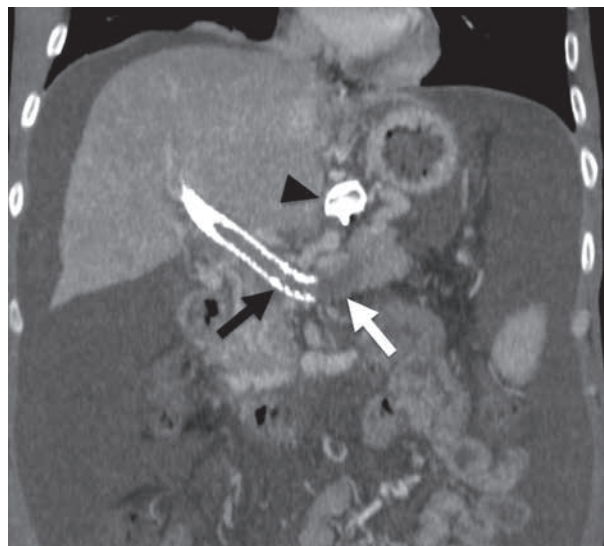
Coronal portal venous phase CT demonstrates extensive thrombus within the TIPSS (black arrow), portosplenic confluence and distal splenic vein (white arrow). Two Amplatzer II plugs have been used to embolise the left gastric vein (black arrowhead). Note the extensive ascites.
